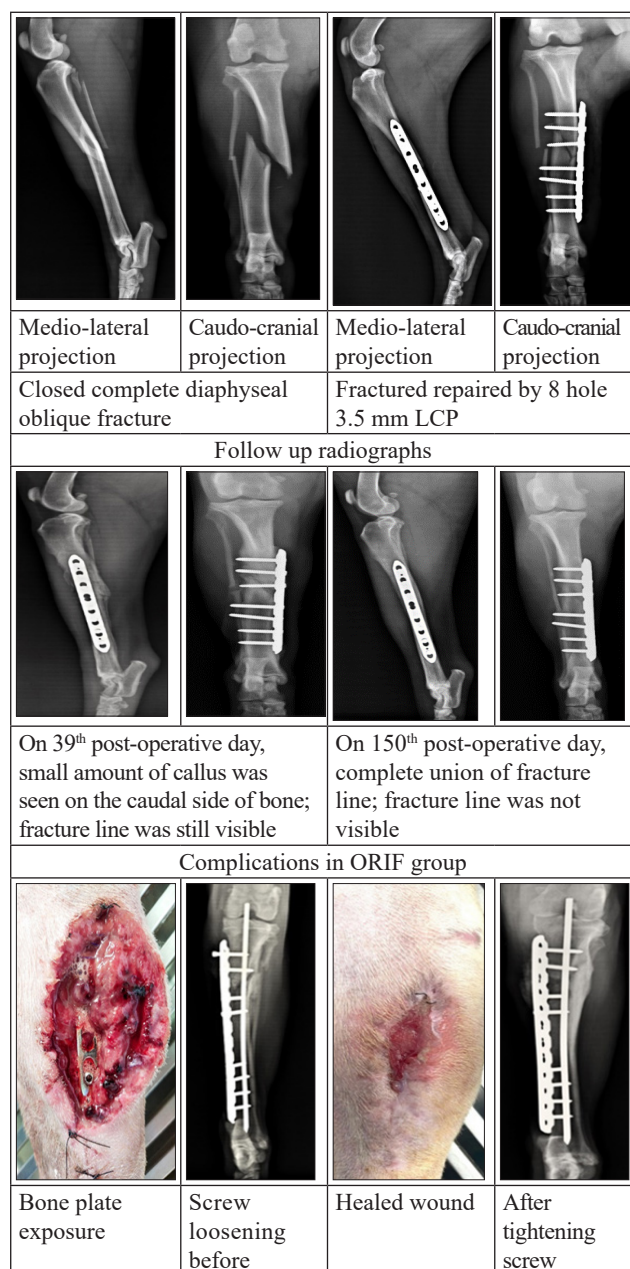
Pre-operative and immediate post-operative radiographs of fracture case managed by ORIF.
